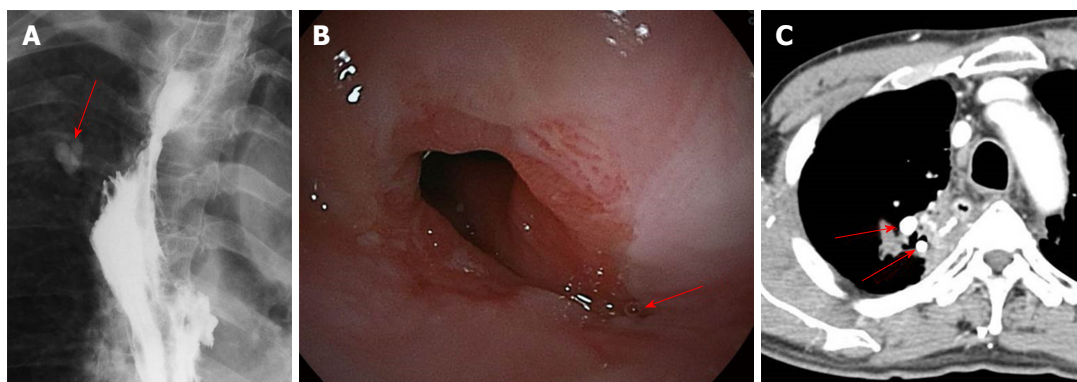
Since the endoscopic occlusion, the patient has not developed recurrence of the fistula for three years. Two endobronchial Watanabe spigots remain (A, arrow); B: In the endoscopic image passed for three years after occlusion, the fistula has disappeared; C: In computed tomography passed for three years after occlusion, two endobronchial Watanabe spigots remain (arrow).
